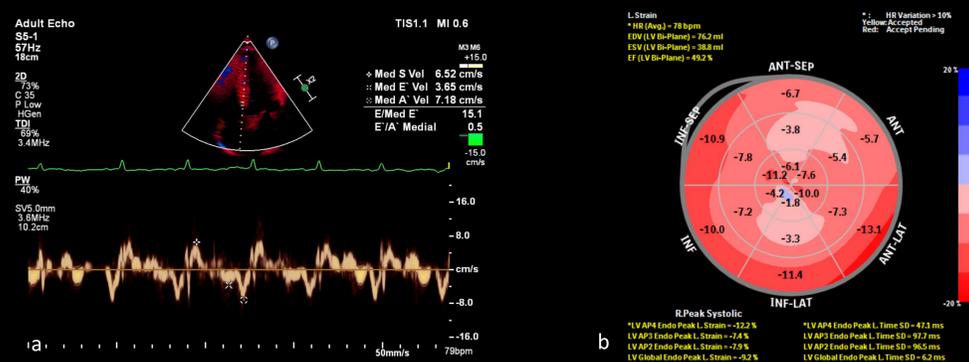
Spectral tissue Doppler imaging (a) showing reduced e' (3.65cm/s) as expected with myopathogenic diseases such as hypertrophic cardiomyopathy. Longitudinal strain bull's eye plot showing reduced longitudinal strain predominantly in the mid and apical areas of the left ventricle suggestive of apical hypertrophic cardiomyopathy.
